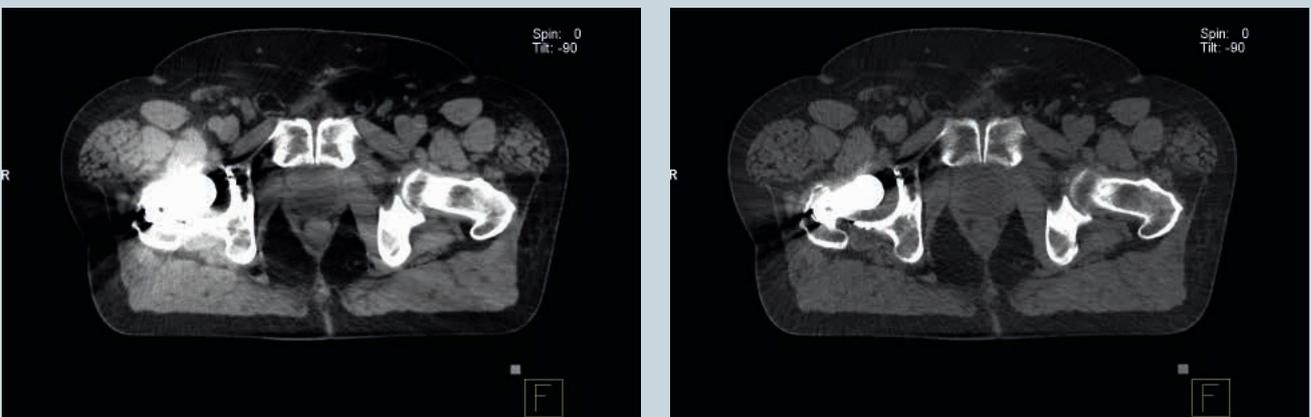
Left: standard 120 kV CT scan for RT planning of the prostate loge. Right: 120 keV DE Monoenergetic image with improved delineation of the target volume and significant reduction of artifact in the area around the TEP.
